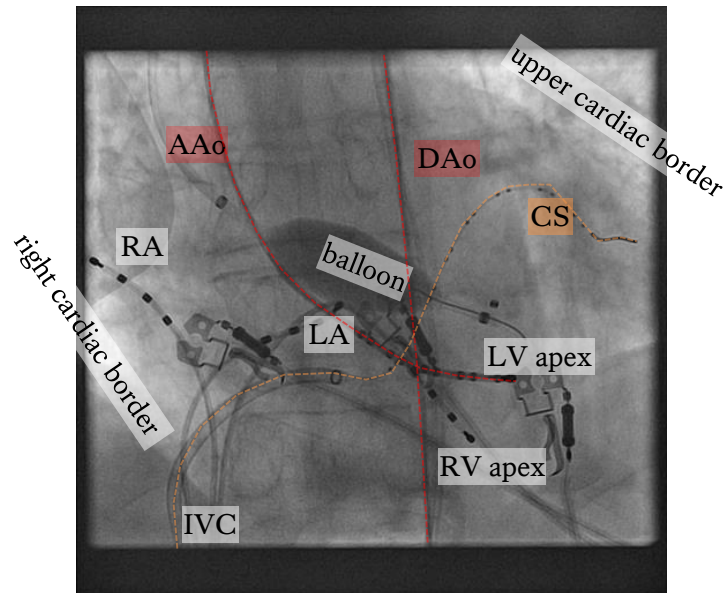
This shows a posterior-anterior view of the heart, with catheters entering the coronary sinus (CS, *orange dashed*), left atrium (LA), right atrium (RA), left ventricle (LV), and right ventricle (RV) via the inferior vena cava (IVC) and EnSite™ balloon, roving catheter and pressure catheter inserted in the LV via the descending and ascending aorta (DAo, AAo, *red dashed*). The devices can be seen with excellent visibility in the X-ray, but there is poor visibility of the heart itself with only some regions of its epicardial border that can be delineated. The CS and aorta catheter can be used for registration.
